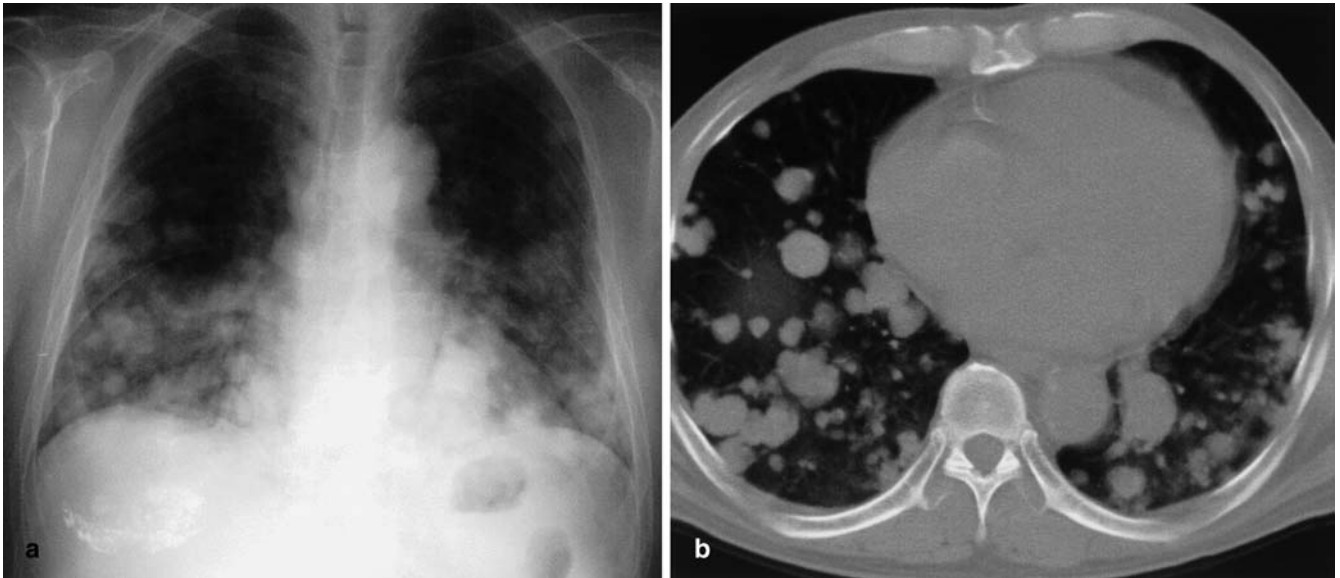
Lung metastases. a Chest radiography and b chest CT show numerous nodules in both lungs. The nodules tend to be more numerous in both lower lungs than in the upper lungs. Note a parse Lipiodol-laden mass in the liver on chest radiography
